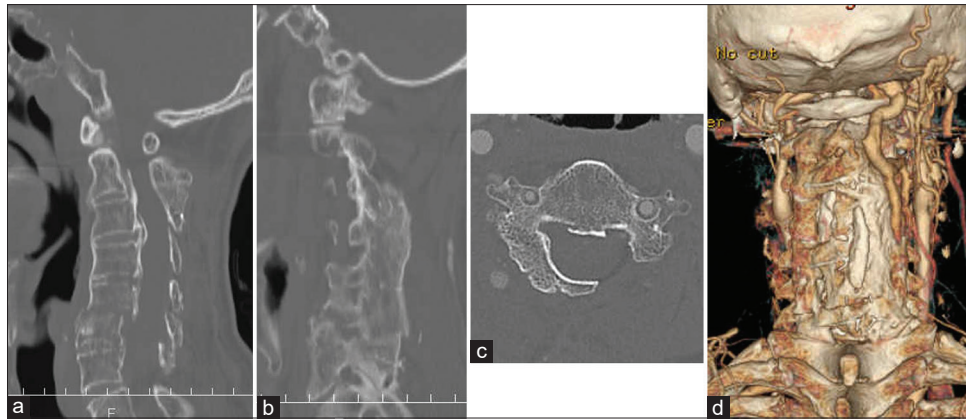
Initial computed tomography image. (a) Midline sagittal image. (b) Parasagittal image. (c) Axial view. (d) Three-dimensional computed tomography
